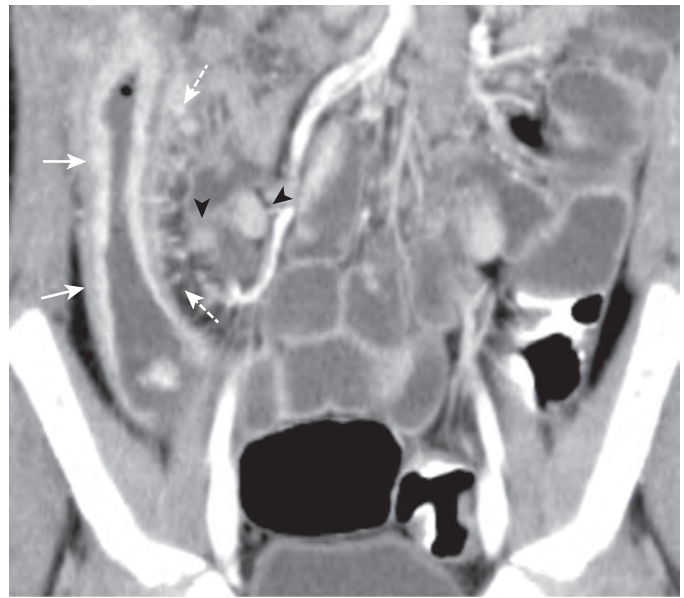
Lymphadenopathy. An 8-year-old girl with Crohn's disease. Coronal reformat image from a contrast-enhanced CT scan of the abdomen and pelvis. There is bowel wall thickening and hyperenhancement of the terminal ileum (solid arrows). Multiple enlarged mesenteric lymph nodes are present in the right lower quadrant (arrowheads). Engorgement of the vasa recta is also noted (dashed arrows).
